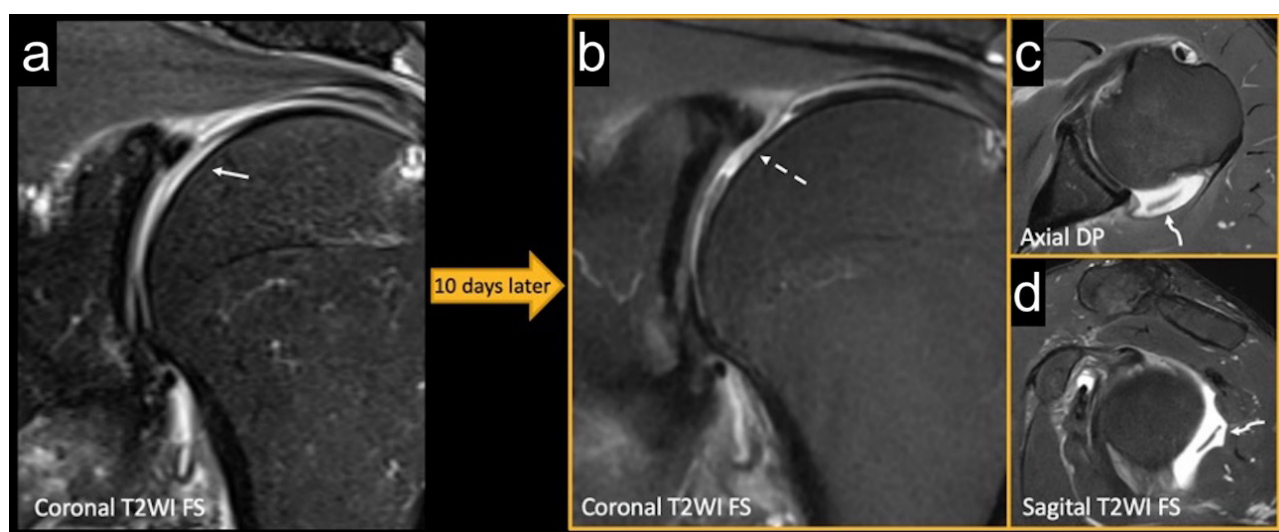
A 57-year-old male with acute pain after serving in a game of tennis. (A) Initial MRI scan showing a focal lesion suggesting chondral delamination in the humeral head (arrow), without subchondral signal alterations, and joint effusion with synovitis and pericapsular edema. (B–D) MRI scans acquired ten days later, after symptom worsening, highlighting the appearance of chondral erosion/detachment (dashed arrow) with a chondral flap displaced to the posterior joint recess (curved arrows).
